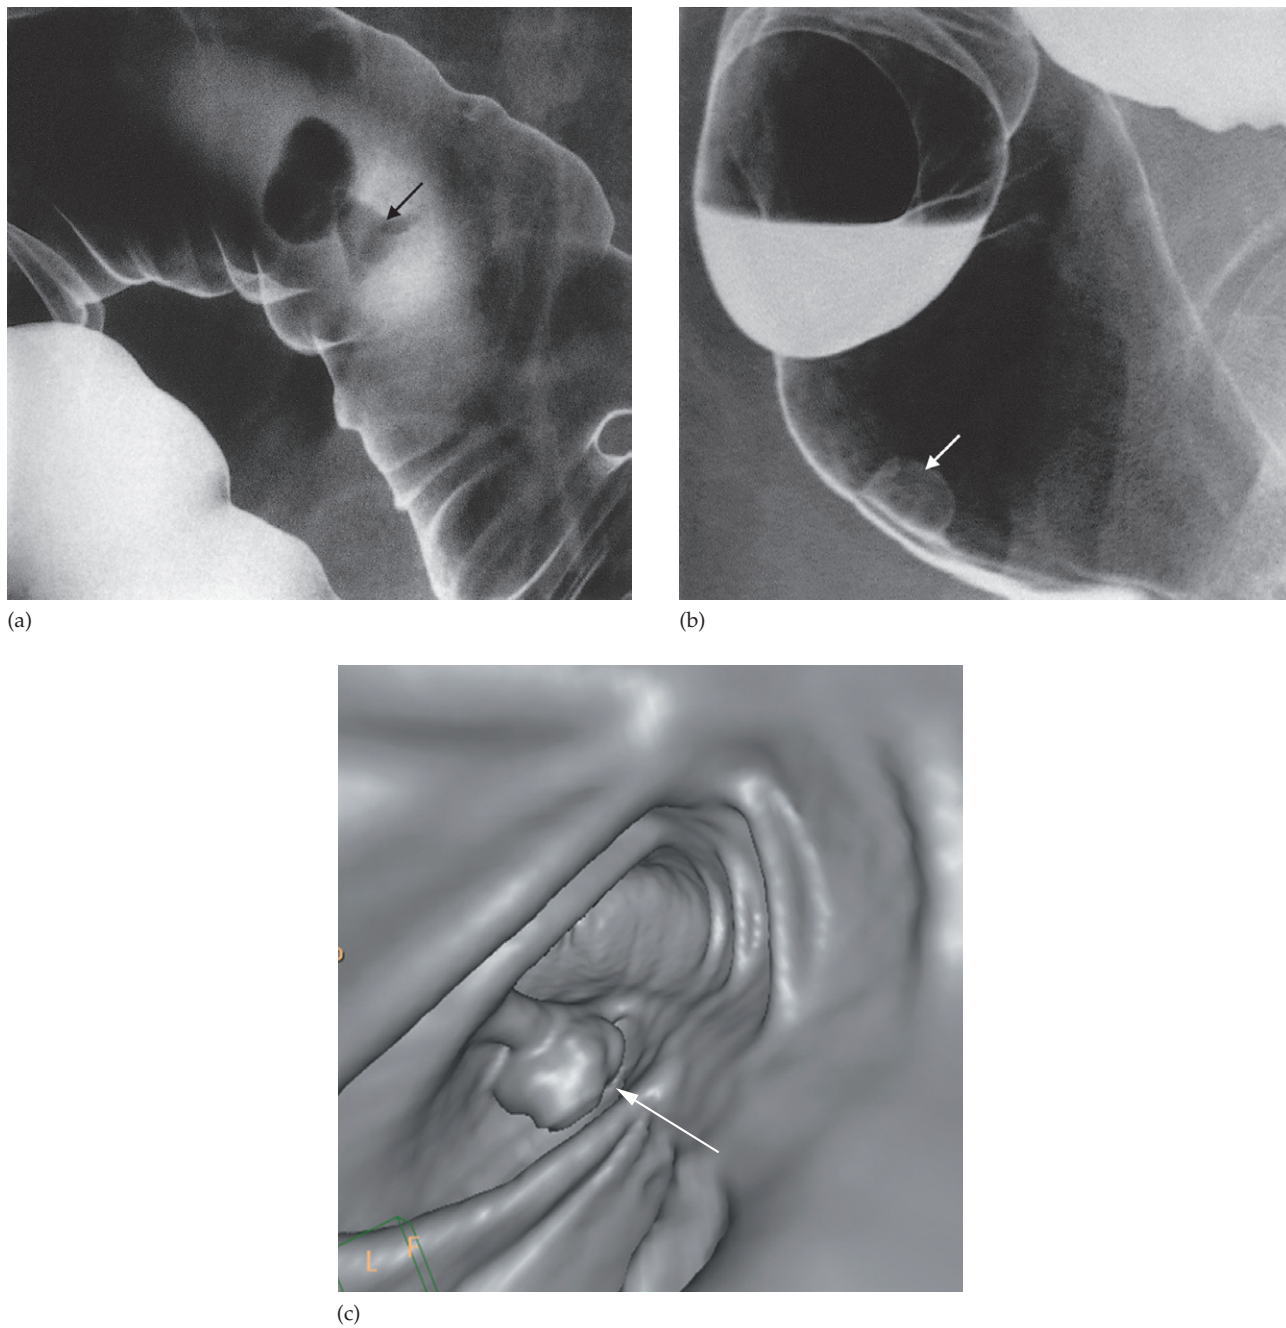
Polyps. (a) Pedunculated polyp (arrow) outlined by barium in the sigmoid colon. (b) Sessile polyp (arrow) in the rectum. (c) CT pneumocolon of a sessile polyp (arrow) in large bowel.
